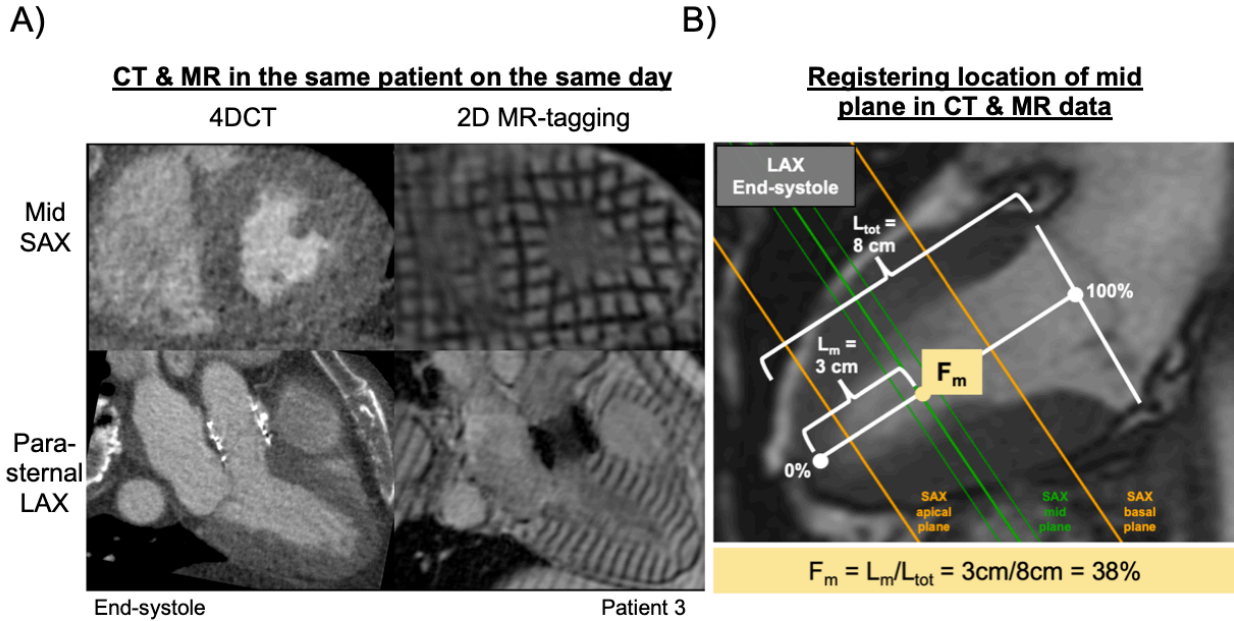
A) On the left is a mid-short-axis (SAX) view and below it a parasternal long-axis (LAX) view from a subject's 4DCT exam at end-systole. On the right are the same views for the same subject from the 2D MR-tagging exam. B) To register the location of the mid plane in the CT and CMR data, its normalized position,  $F_m$ , was measured in 3 LAX MR views at end-systole and averaged. The corresponding location was found in the CT data.
